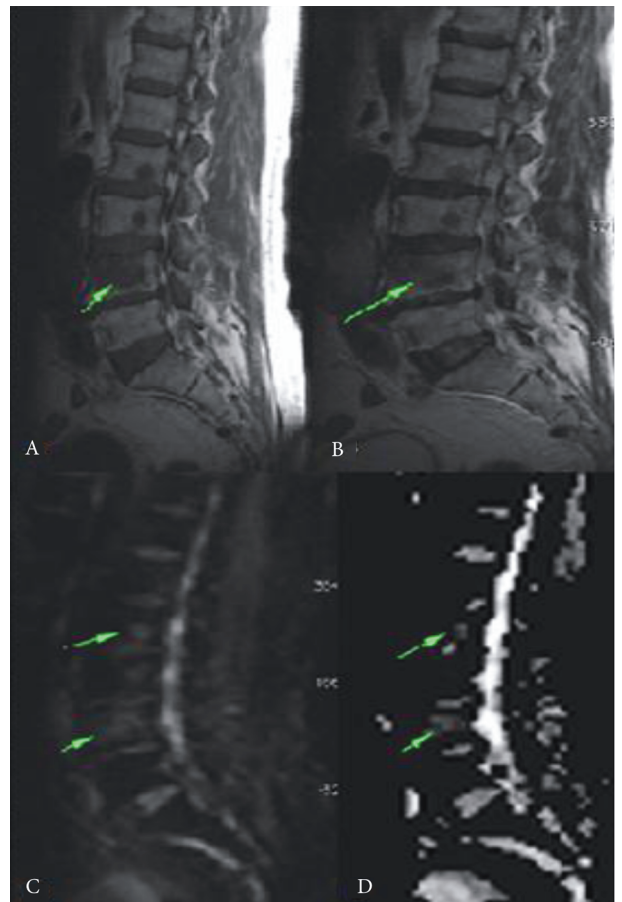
A–D. Widespread sclerotic metastases in the vertebrae of a 64-year-old patient with carcinoma of the prostate, the biggest one at the corpus of the L4 vertebra. The T1-weighted axial MR image (A) and T2-weighted axial MR image (B) show hypointensity in the lesions (arrow). DWI (C) shows hyperintensity in the lesions (arrows). The ADC map (D) shows hypointensities in these lesions due to restricted diffusion (arrows). The mean ADC value is $0.54 \times 10^{-3} \text{ mm}^2/\text{s}$ at the ADC measurement from the lesion at L4 vertebra, supporting metastasis.
